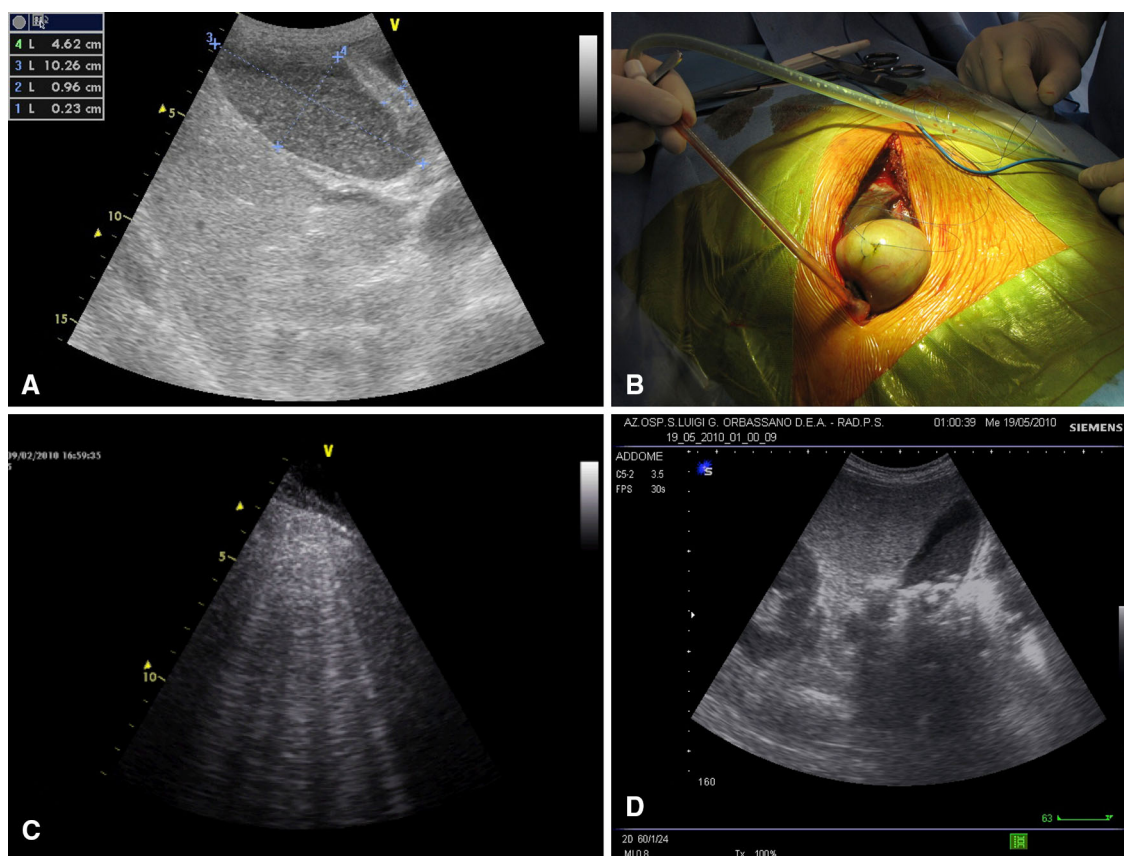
a In a case of septic shock, the US abdominal examination shows thickened gallbladder wall (dist. 2 of 0.96 cm) with small cavitations within the wall (dist. 1 of 0.2 cm) and echoic material inside the lumen. The size of the gallbladder is 4.6×10.3 cm. b Intraoperative picture of the same patient shows enlarged but not inflamed gallbladder which was not a source of sepsis. c Parallel lung ultrasound shows multiple B-lines. The patient was not fluid overloaded but in septic shock with low preload. B-lines indicate loss of aeration, but based only on this artifact, pulmonary edema and ARDS are hardly distinguishable. Consideration of adjunctive
